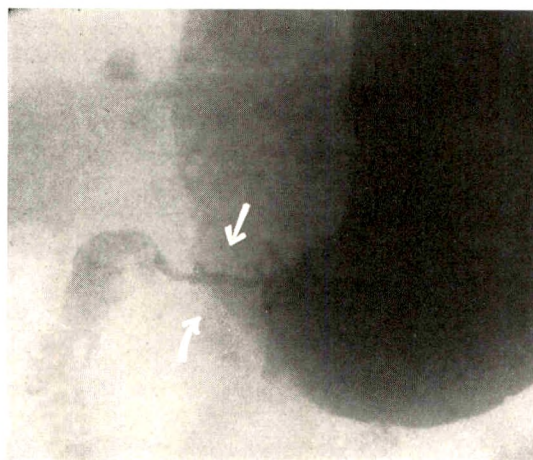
Case II. A roentgenogram seven months later, showing a large annular carcinomatous filling defect at the pylorus, the lesion extending up into the antrum.
